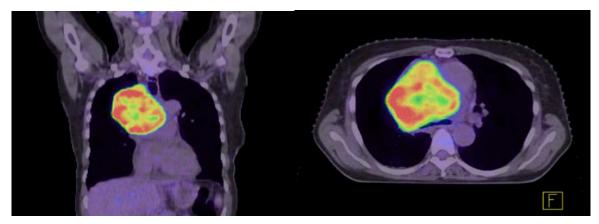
¹⁸FDG-PET-CT images before the KRT.
